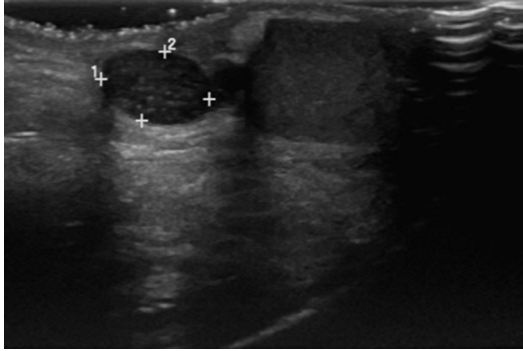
Ultrasound image demonstrating torsion of the testicular appendage. Note the heterogenous appearance of the appendage relative to the normal-appearing testicle. This patient was found to have a classic “blue-dot” sign on physical examination.
